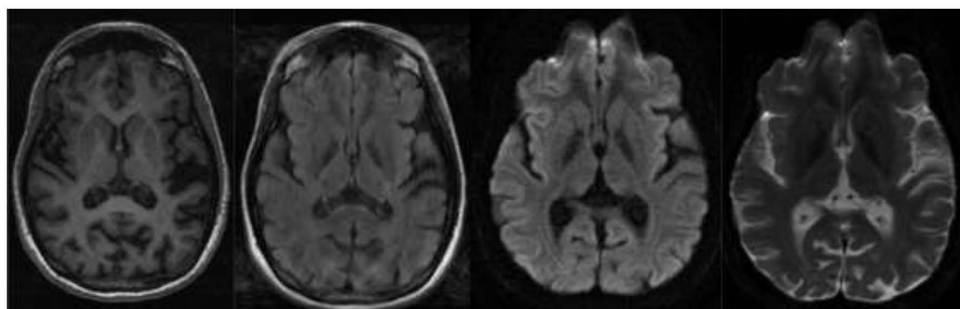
Brain MR T1, T2 FLAIR, and diffusion weighted imaging sequences showing bilateral globus pallidus iron deposition and posterior atrophy in the parietal and occipital lobes
